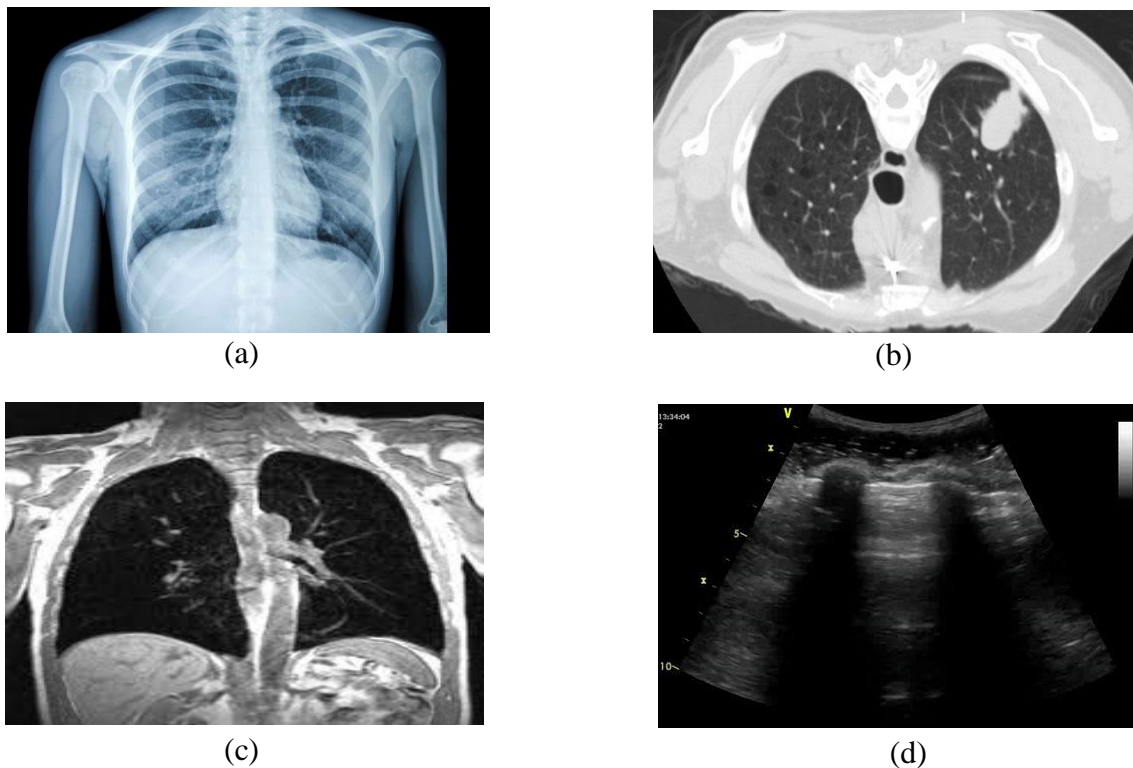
Different Medical Imaging Techniques for lung visualization. (a) X-ray. (b) CT-scan. (c) MRI. (d) Ultrasound
